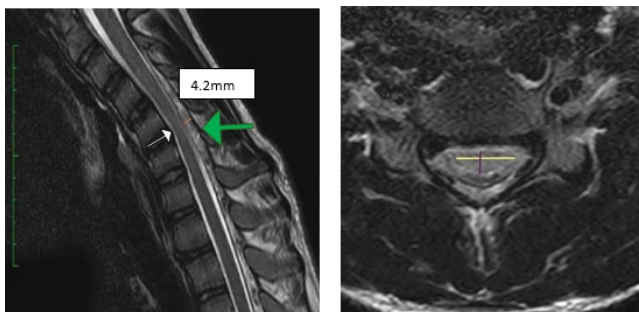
MRI of cervical spine in flexion. Sagittal T2-weighted image (a) shows crescent shaped mass (green arrow) in the posterior epidural space, which is due to 4.2mm anterior shifting (orange line) of the posterior cervical dura and compression, flattening, atrophy and myelomalacia of the cervical cord at the apex of kyphosis (white arrow). Axial image (b) at the same level shows severe cord flattening.
